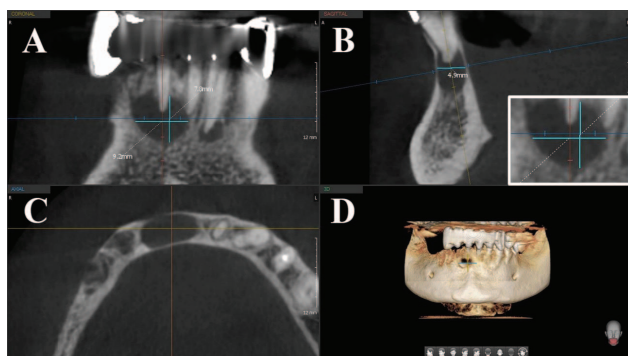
The images of one representative large-size periapical lesion (teeth 41): A) Coronal cross-section of the root; B) Sagittal cross-section of the root; C) Axial cross-section (largest buccal size); D) 3D reconstruction (Dental Cone Beam Computed Tomography – CBCT). The insert represents a higher magnification of the measured lesion size.
